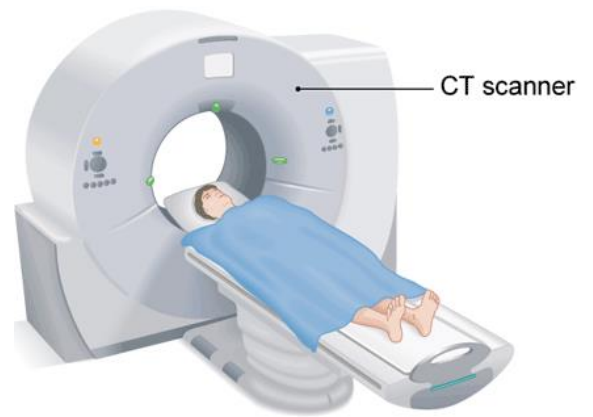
CT scanning procedure [56]
